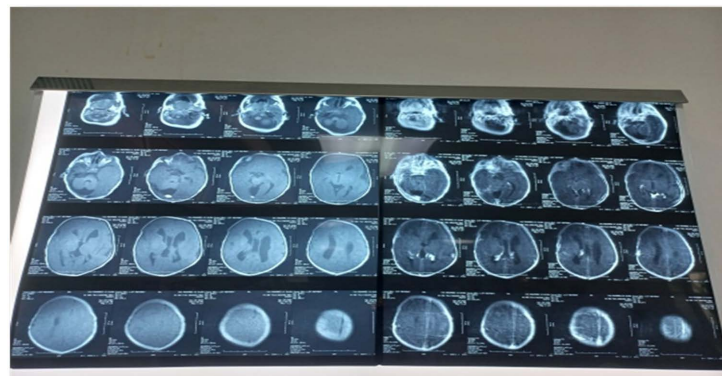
Brain MRI image.
